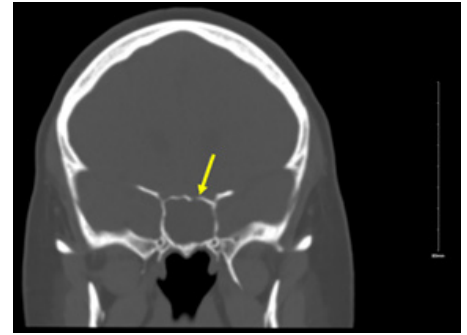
CT Head showing thinning/defect of Left Sphenoid Sinus Roof (arrow).
